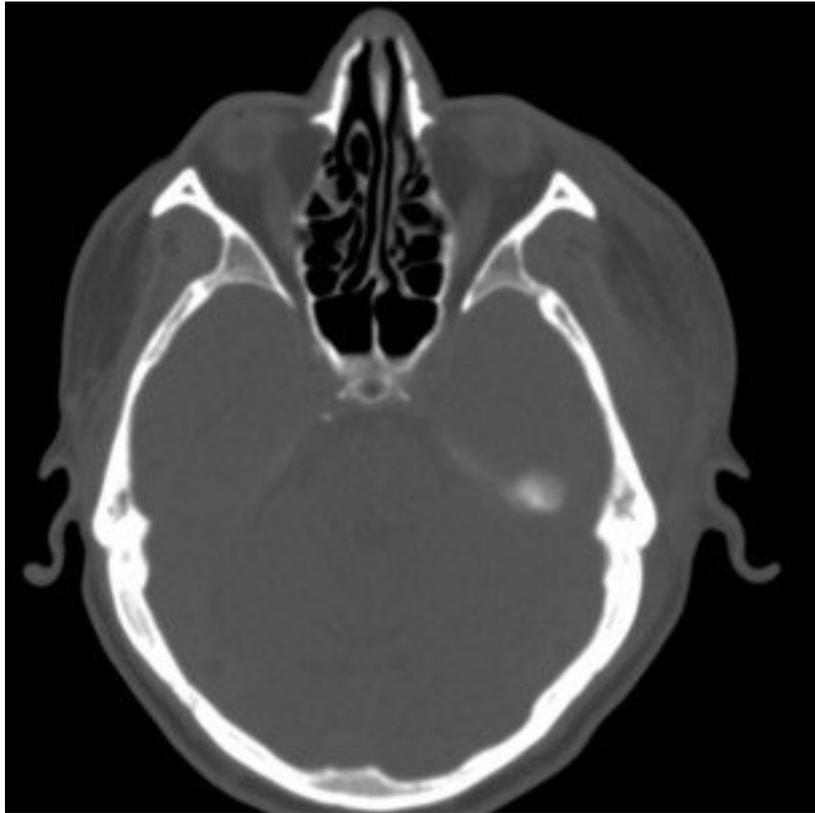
(a, b): Computed tomography of the temporal bones (middle and inner ear)
